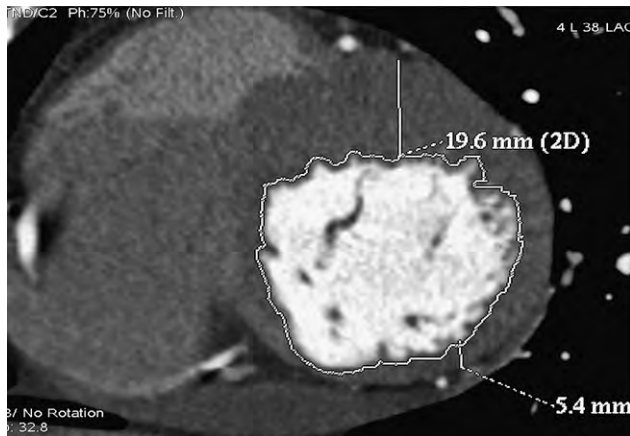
Short-axis cardiac computed tomographic image demonstrating asymmetric myocardial hypertrophy. The measurements shown are those of the anterior septum (19.6 mm) and inferolateral wall (5.4 mm).
